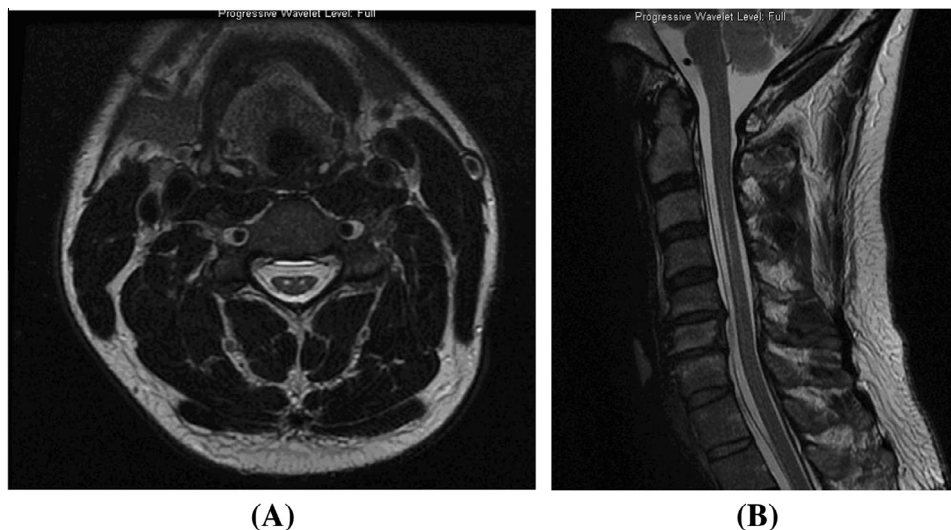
Patient 1. (A) Axial T2-weighted MRI of the cervical spine showing evidence of signal change in the region of the anterior horns which is out of keeping with the minimal compression exerted by the cyst at this level. (B) Sagittal T2-weighted MRI of the cervical spine showing signal change in the cervical cord between levels C3–C7, which is superior to the maximal compression of the cyst which is predominantly in the thoracic spine.
